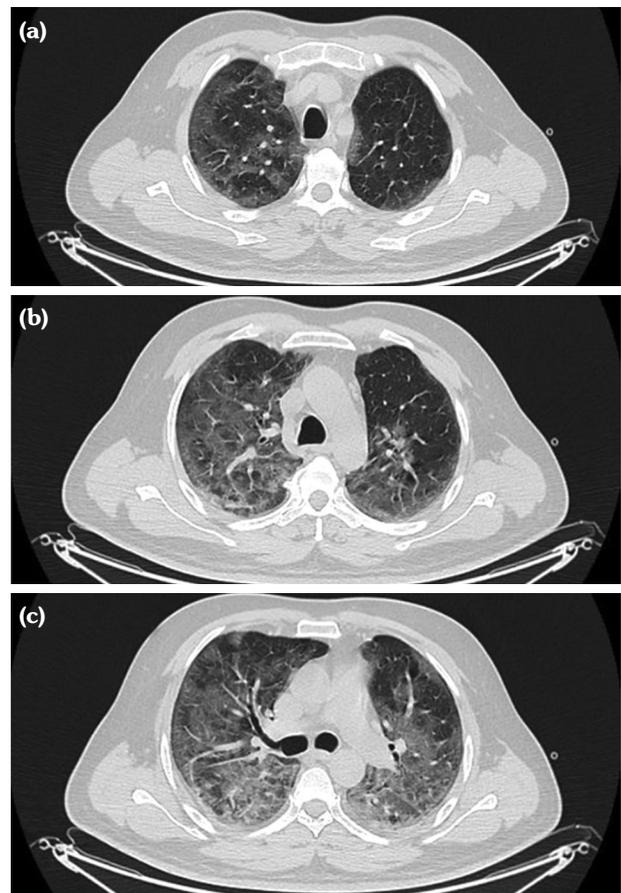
CT images obtained on August 12, 2020. (a) A CT image showing diffuse patchy parenchymal infiltrations in upper lobes of lungs. (b) Ground-glass opacities dominantly in right upper lobe. (c) Diffuse ground-glass opacities and parenchymal infiltrations.
